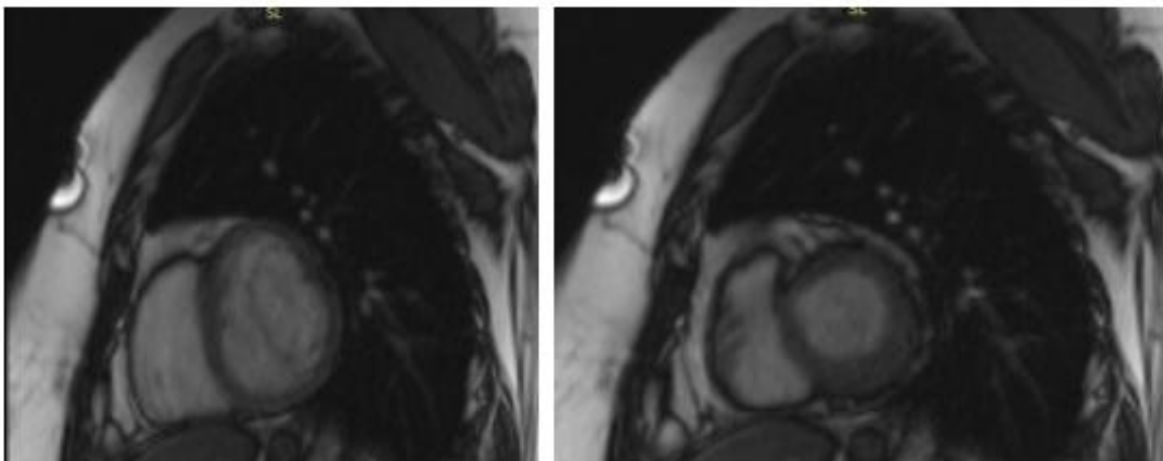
Short axis view of cardiac MRI revealing an LVNC (diastole and systole)
